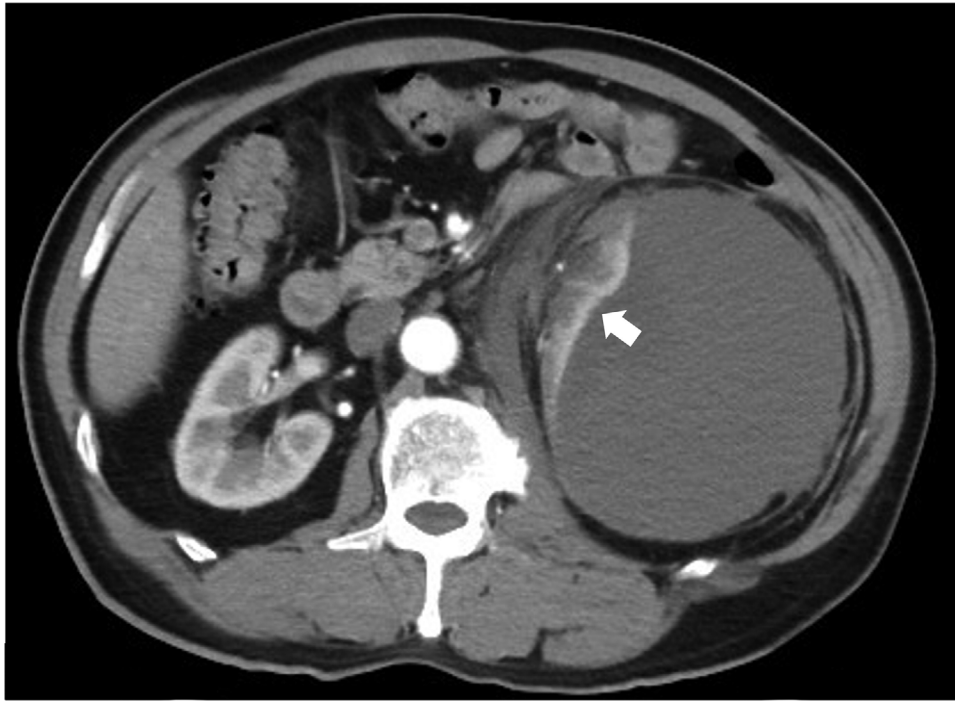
Axial view of contrast-enhanced computed tomography of the abdomen showing a large left perirenal hematoma of approximately $14 \times 10 \text{ cm}^2$ in size compressing the left kidney (arrow).
